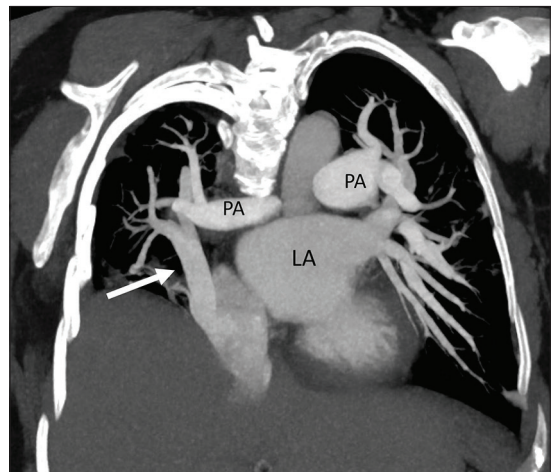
Coronal oblique maximum intensity projection computed tomography angiography image demonstrates that all of the right-sided pulmonary veins are draining into the inferior vena cava via a vertical vein (arrow), creating a left-to-right shunt. Note the normal communication between left atrium and left-sided pulmonary veins
